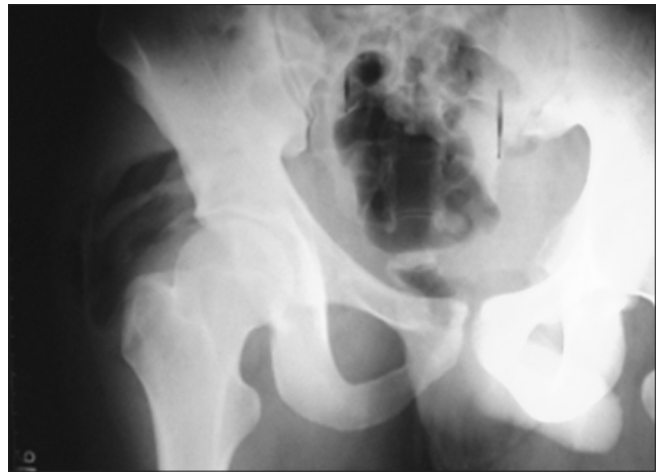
X-ray pelvis anterior posterior view shows evidence of IM gas lucencies, with soft tissue edema in the right gluteal region. No bone involvement
